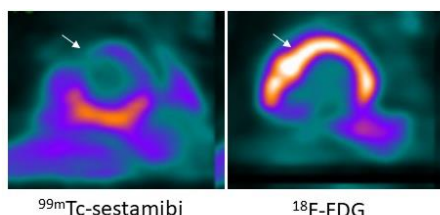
Cardiac sarcoid. On the myocardial perfusion image (left), there is a defect (arrow) in the mid anterior wall of the left ventricle. On the  $^{18}\text{F}$ -FDG image (right), there is increased activity (arrow) in the same region. This pattern is virtually diagnostic of cardiac sarcoid.
